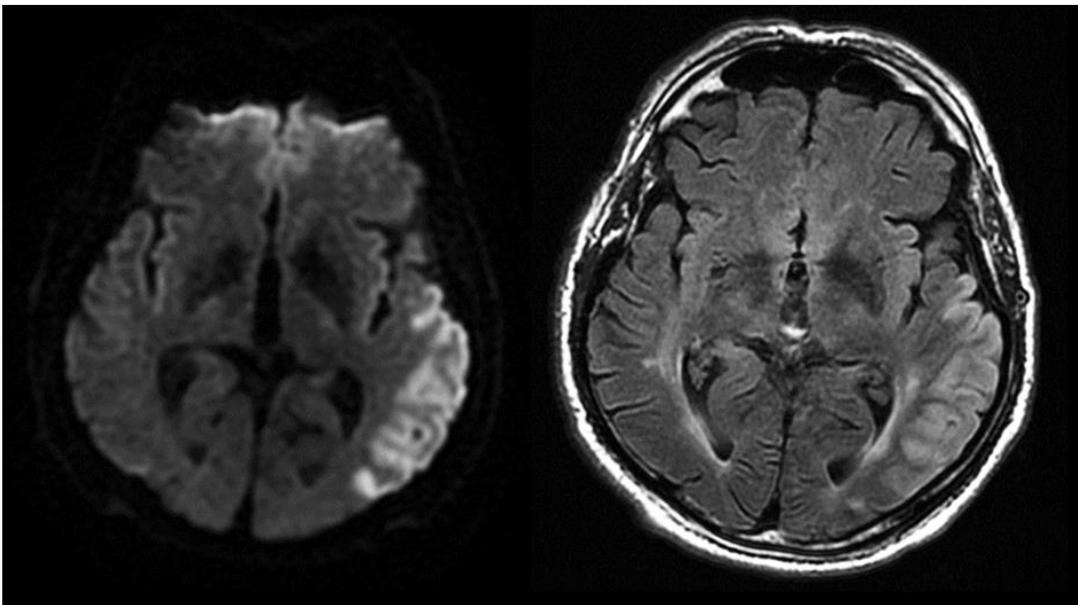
Matched DWI-FLAIR pattern of a left temporal infarct.
